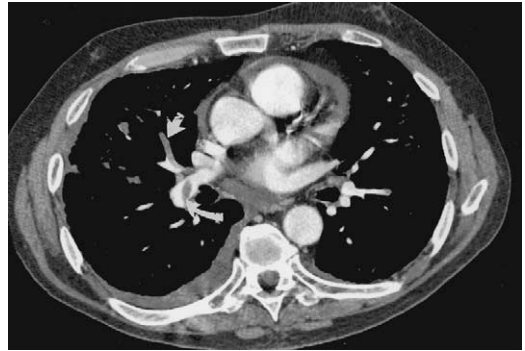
Acute PE. Multidetector spiral CT image shows a complete filling defect in the medial segmental artery of the right middle lobe (straight arrow) and a partial filling defect in the right lower lobe artery (curved arrow).
